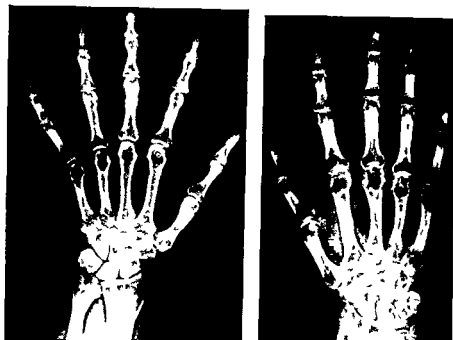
Case 6 G S Roentgenograms of both hands of patient demonstrating the advanced osteoporosis of the right phalanges carpus and even the bones of the forearm
